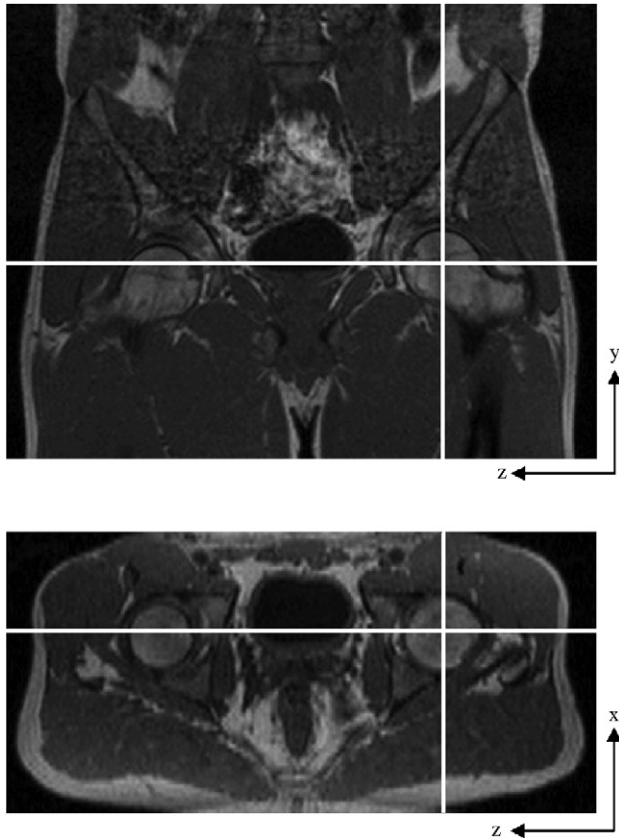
Example coronal (top) and transverse MRI images through a pelvis showing a first approximation to the HJC location and the orientation of the pelvic coordinate system: z -axis passing through the ASISs from left to right, y -axis perpendicular to the plane containing the x -axis and the mid point of the PSISs and pointing superiorly, x -axis perpendicular to the yz plane, pointing anteriorly. Note that the coordinate system origin is located halfway between the two ASISs (Wu, 2002).
